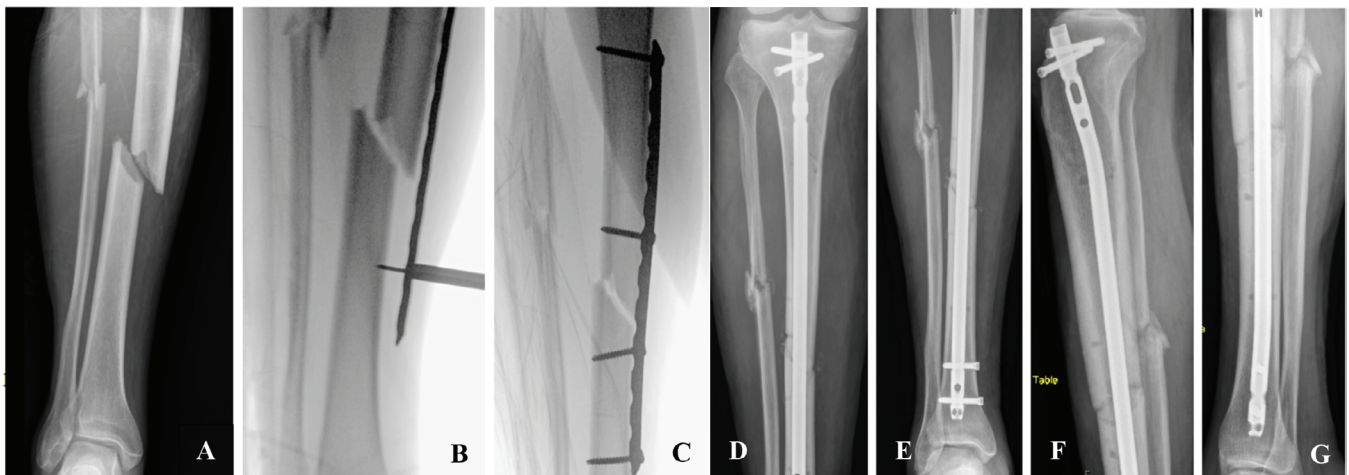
to 1G. Case example. The use of temporary plate fixation for stabilization of tibia fractures. These radiographs were obtained from a 72-year-old male who suffered a polytraumatic event after a high-speed motor vehicle collision. He sustained an aortic injury resulting in retroperitoneal hemorrhage in addition to multiple orthopedic injuries including open left femur, tibia, and fibula fractures as well as closed right tibia and fibula fractures. The preoperative anteroposterior (AP) radiograph (1A) depicts acute comminuted transverse fractures of the tibia and fibula. Intraoperative fluoroscopic images show positioning of the temporary plate (1B) followed by achievement of satisfactory alignment and attachment of plate with four bicortical screws (1C). Twenty-nine days later, the temporary plate was removed, and the tibia fracture was definitively treated with MN. Postoperative AP (1D, 1E) and lateral (1F, 1G) radiographs demonstrate interval healing and improved alignment of the proximal (1D, 1F) and distal (1E, 1G) tibia.
